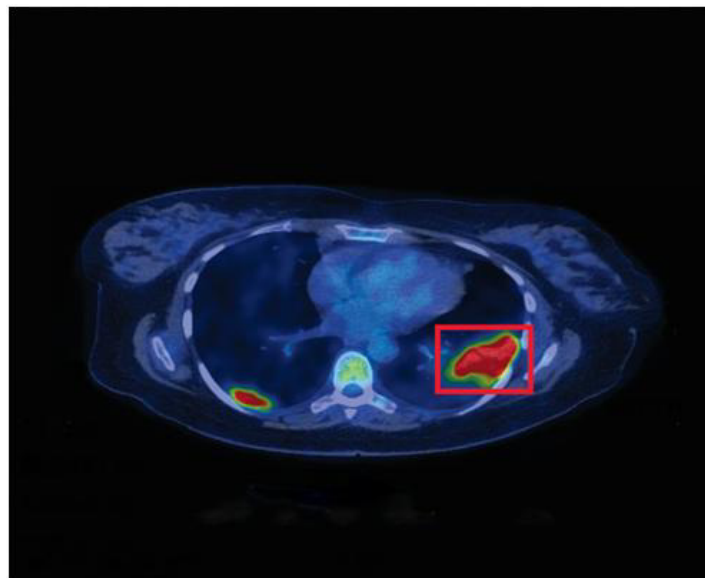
The PET-CT examination revealed — multiple areas of infiltration, with a "frosted glass" appearance located predominantly in subpleural, peripheral, and peri fissural areas, demonstrating SARS-COV-2 antecedents.
